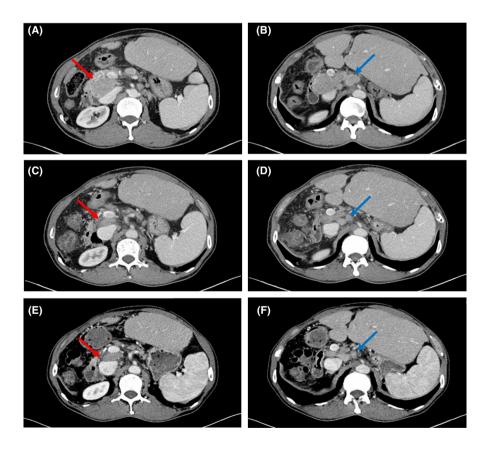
Computed tomography scan before and after treatment. A, B, Computed tomography scan demonstrated multiple enlarged lymph nodes in the hepatic hilar, hepatogastric ligament, and para-aortic areas. C, D Computed tomography scan after three cycles. E, F Computed tomography scan after six cycles. Red and blue arrows indicate two typical enlarged nodes
